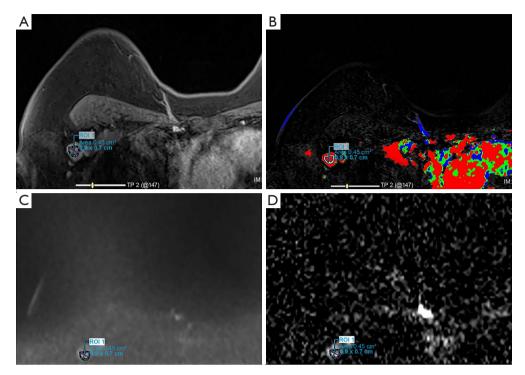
A 50-year-old patient with IDC: (A) contrast-enhanced T1-weighted image, (B) color-coded dynamic contrast material enhanced image, (C) DWI at b =800, and (D) ADC map showing the manually drawn ROI of the largest right axillary node. ROI, region of interest; IDC, invasive ductal carcinoma; DWI, diffusion-weighted imaging; ADC, apparent diffusion coefficient.
